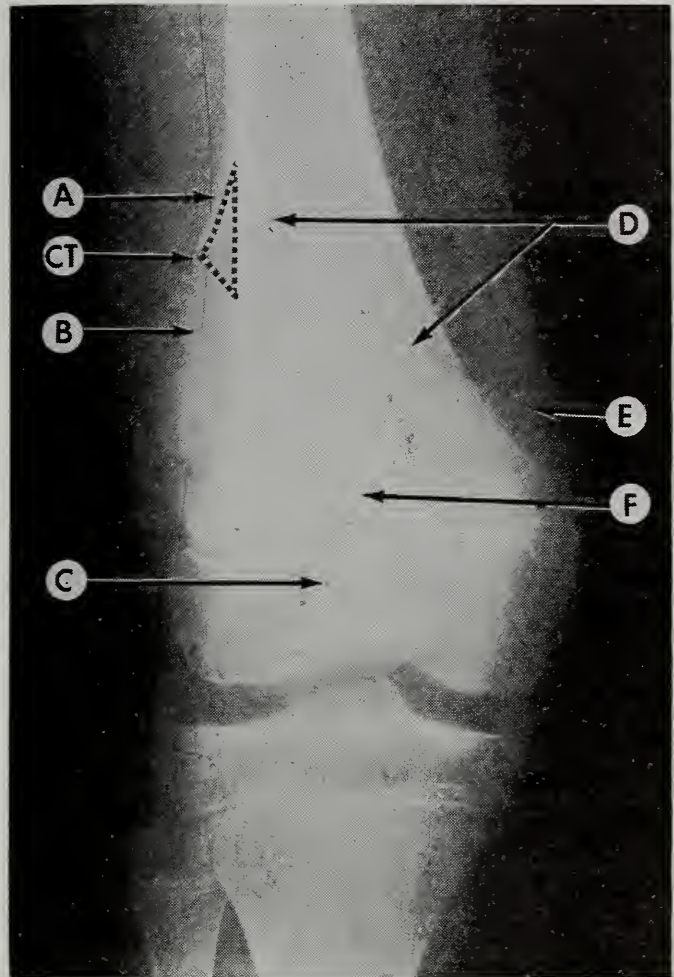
X-ray of a typical aggressive osteosarcoma. A) Outer rim of periosteal reaction, CT) Codman's Triangle, B) Area of tumor breakthrough, C) Tumor violating epiphyseal growth plate, D) Areas of destruction (lysis), E) Periosteal reaction, F) Area of increased density (tumor bone formation).
